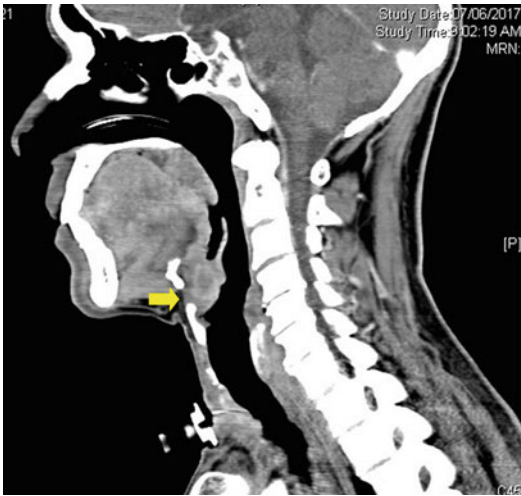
Contrast-enhanced CT neck sagittal image showing a supraglottic tumor almost completely filling the pre-epiglottic space (yellow arrow)
